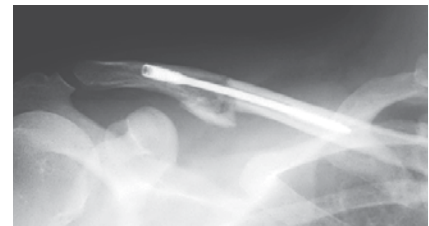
Postoperative Follow-Up Radiograph
